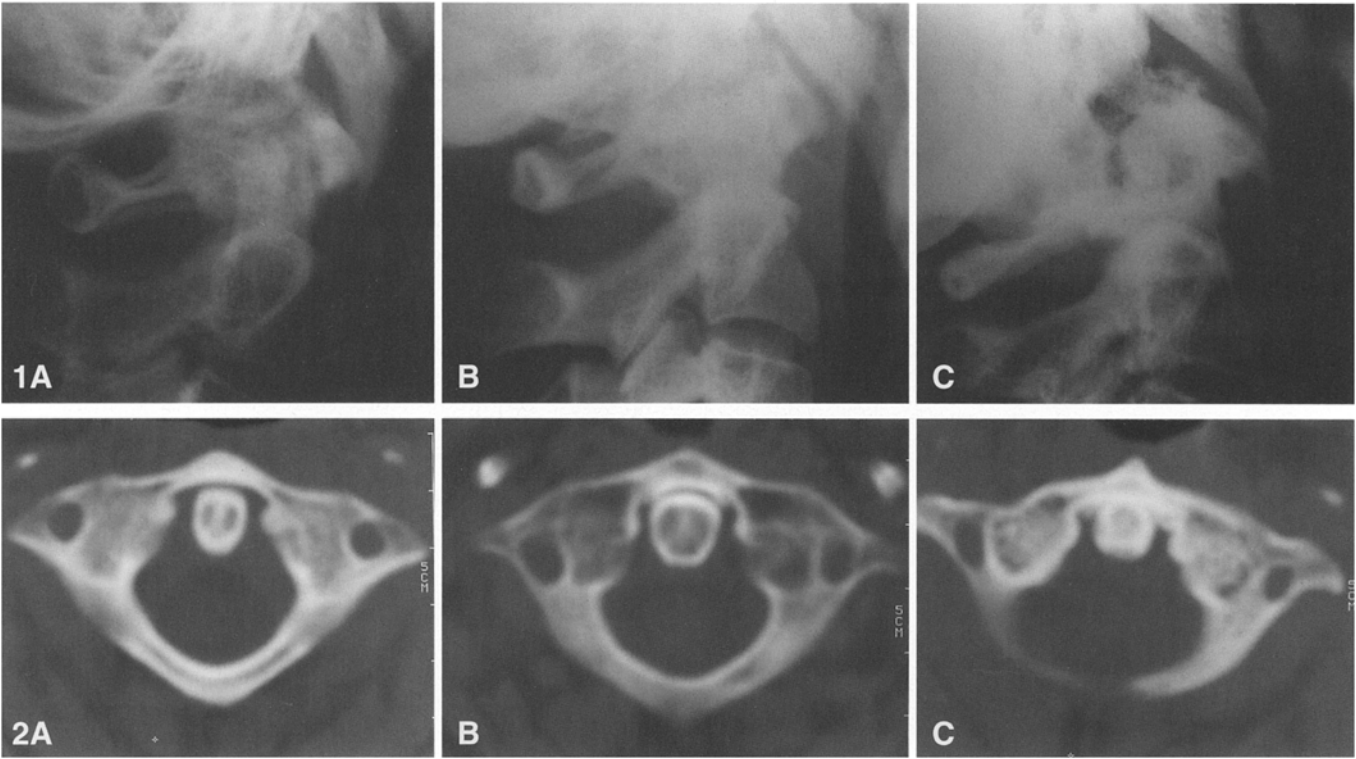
Degree of degenerative involvement at the AO joint as seen on lateral radiographs of the cervical spine. A 0 = normal; B 1 = mild degenerative disease with narrowing and hypertrophy; C 2 = severe degenerative disease with obliteration of the joint space, osteophytes and sclerosis
